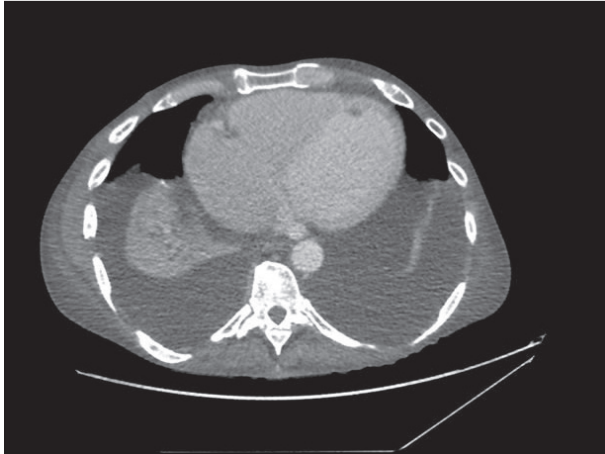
CT Thorax demonstrating cardiomegaly and bilateral pleural effusions
